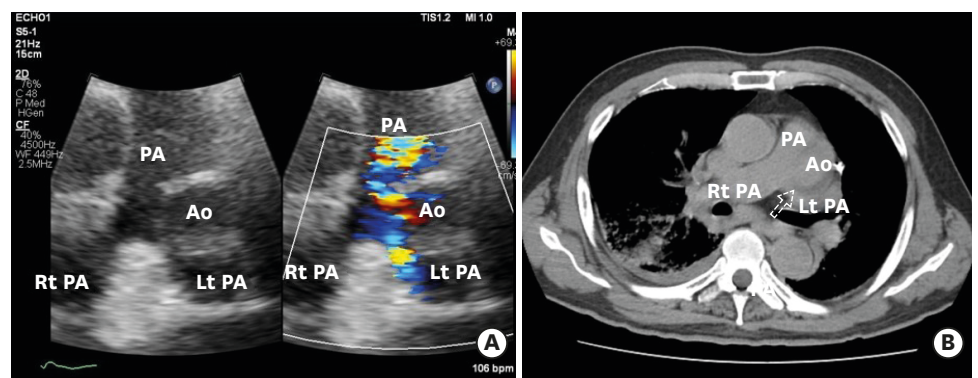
(A) Transthoracic echocardiography. Short-axis view (left panel) shows the aneurysm compressing the Lt PA near the PA bifurcation, and the color Doppler mode (right panel) shows the flow communication between the aneurysm and the PA. (B) Pre-enhanced phase computed tomography showing the aneurysm compressing Lt PA (dotted arrow). It is consistent with the findings of the transthoracic echocardiography. Ao = aortic arch aneurysm; Lt PA = left pulmonary artery; PA = pulmonary artery; Rt PA = right pulmonary artery.
